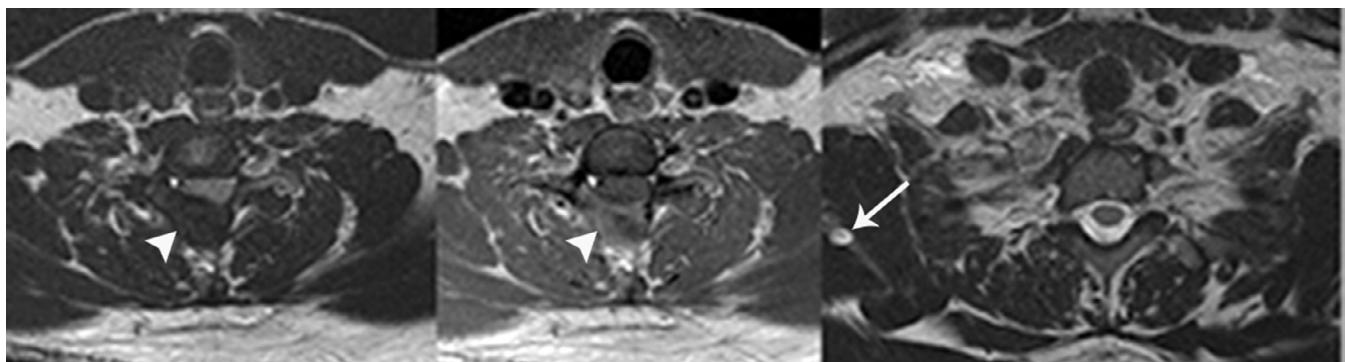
The mass (arrowheads) was isointense to muscle on T2-weighted axial MR image (Left) and showed moderate enhancement on postcontrast axial T1-weighted MR image (Middle). A small right scapula cystic lesion (arrow) was also seen (Right).
